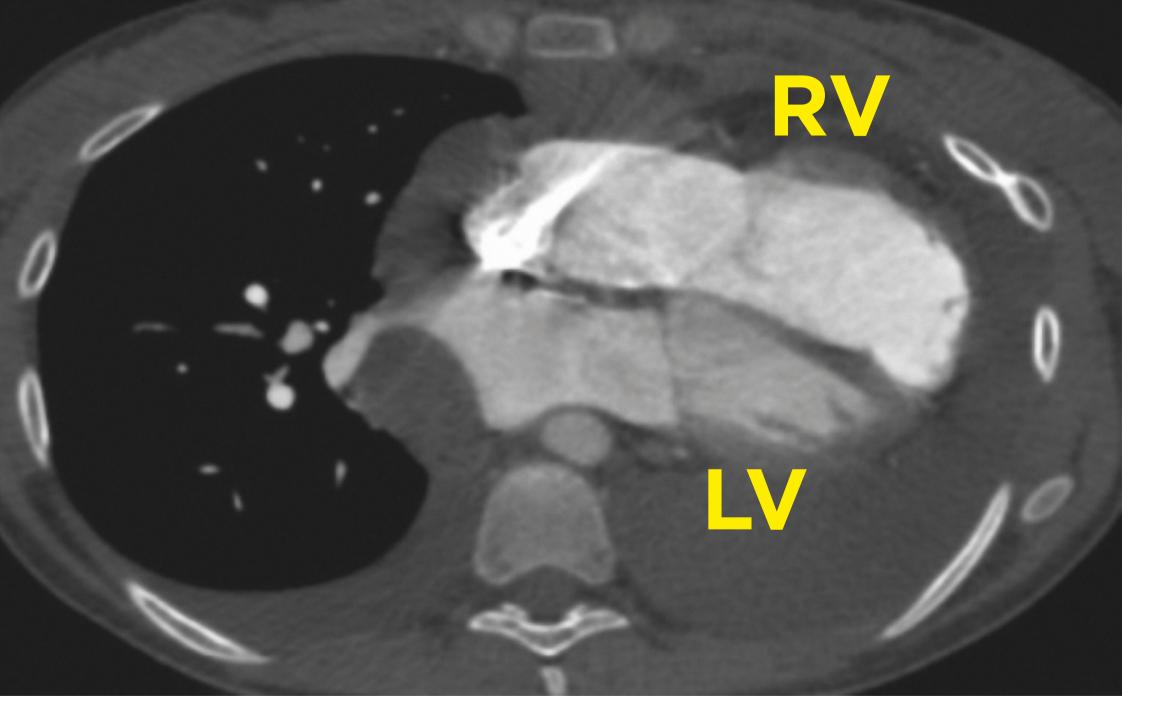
CT scans of the right pulmonary artery (PA) and heart chambers – Right and Left ventricles (RV, LV). Alleviation of right PA stenosis and reduction of RV strain on Pazopanib treatment.
